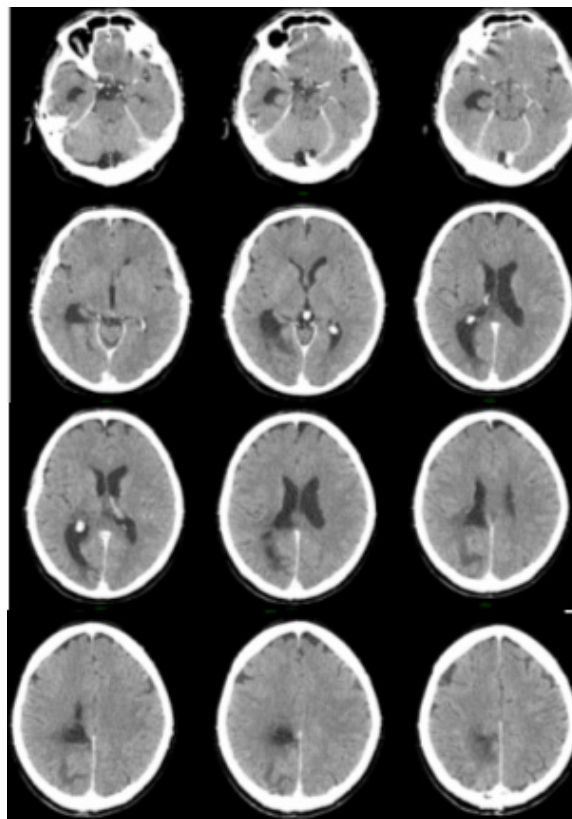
CT of the brain after 10 months of RT- No contrast-reinforcing zones, rather encephalomalacic areas on the right frontal parietal, was visualized.
